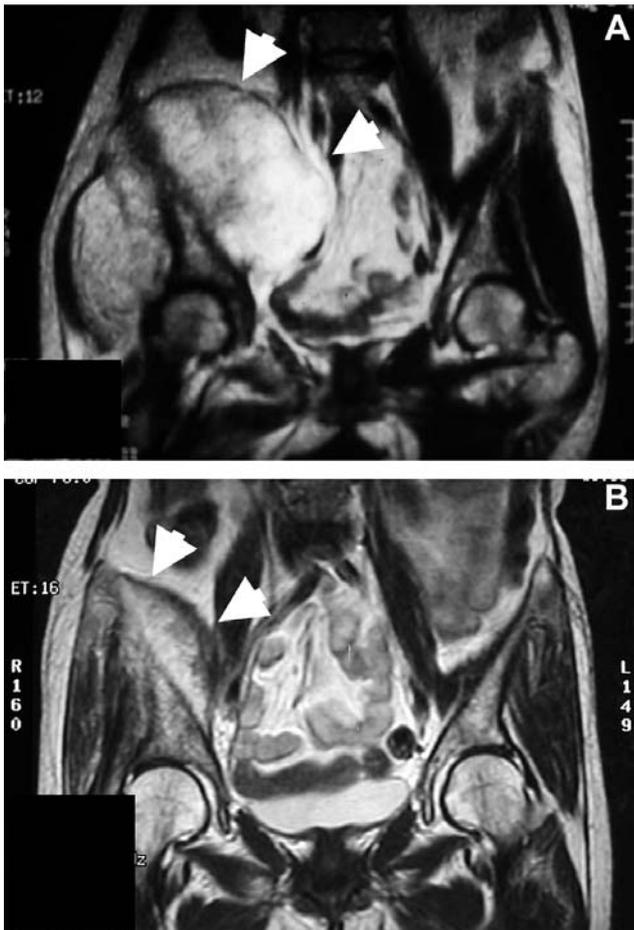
Magnetic resonance imaging (MRI) findings before and after chemotherapy. A. Bone tumor of the ilium with a large soft tissue mass. B. Marked tumor shrinkage after three courses of chemotherapy. Arrows indicate the soft tissue mass.
